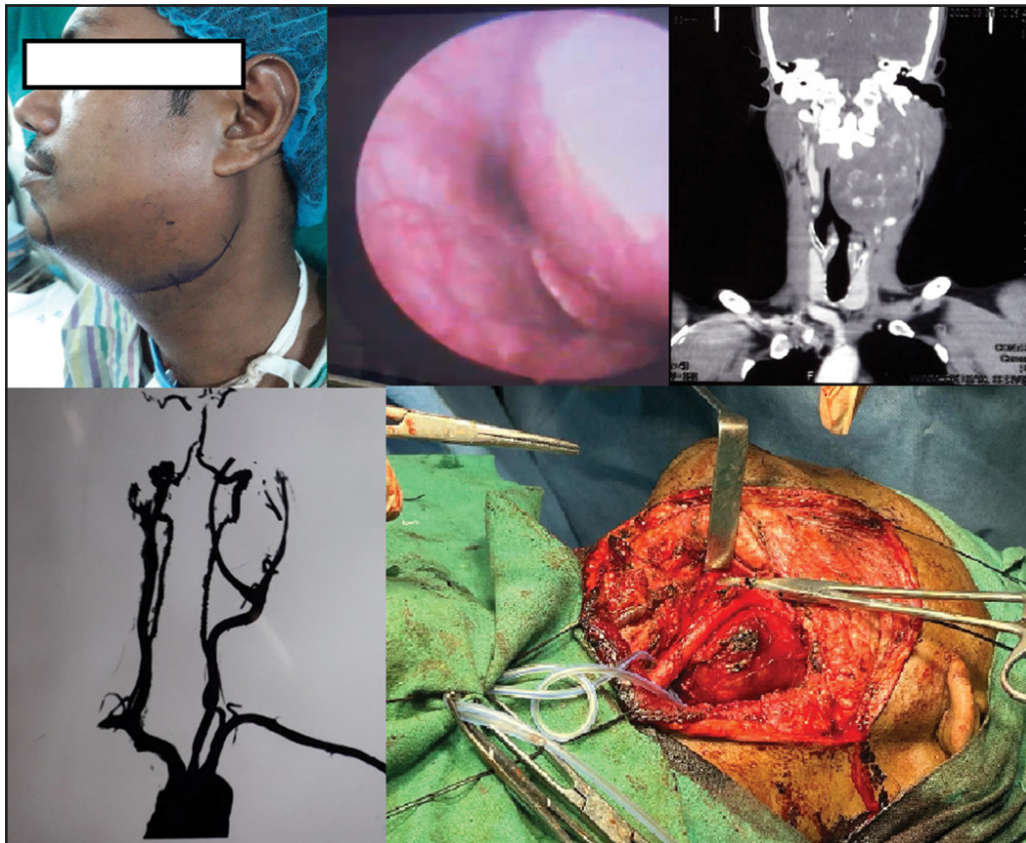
(left to right, top row) 4a. Clinical Picture of the patient; 4b. Rigid laryngoscopy showing a mass completely occluding the airway in the supraglottic region, with the epiglottis visible anteriorly and a shadow of the right pyriform sinus seen posteriorly; 4c. CE-CT of the lesion in coronal view; (bottom row) 4d. CT angiography of neck vessels showing splaying of ICA and ECA; 4e. Intra operative picture showing the lesion after dissection.
